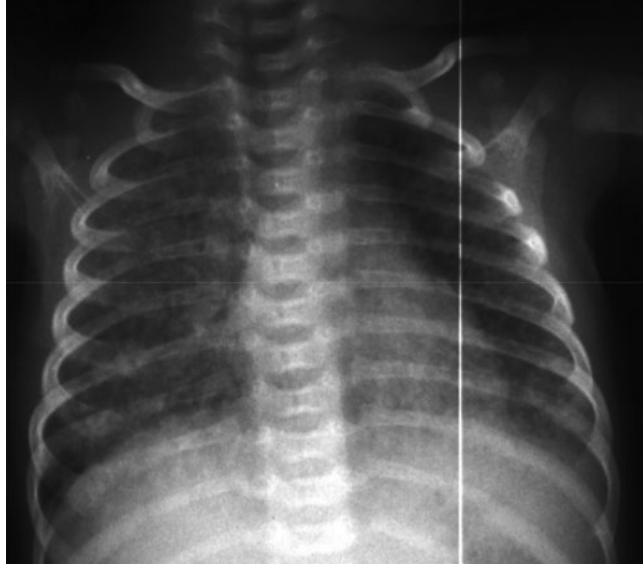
Chest X-ray of a young infant with *Chlamydia trachomatis* pneumonia. Note the bilateral patchy infiltrates.
